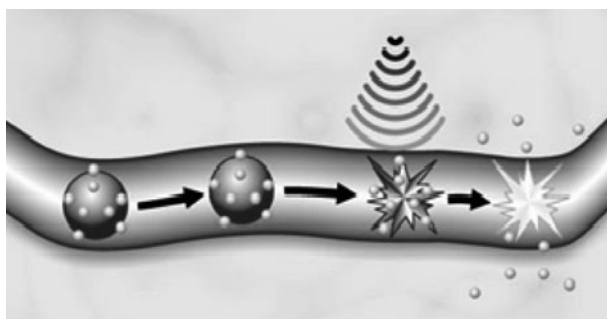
Gas-filled microbubbles (*purple*) covered with DNA (*green*) pass harmlessly and uneventfully through blood vessels until they are exposed to ultrasound. Then, the bubbles burst, causing not only the release of the DNA but also the opening of holes in the cells that line the vessel [37]
